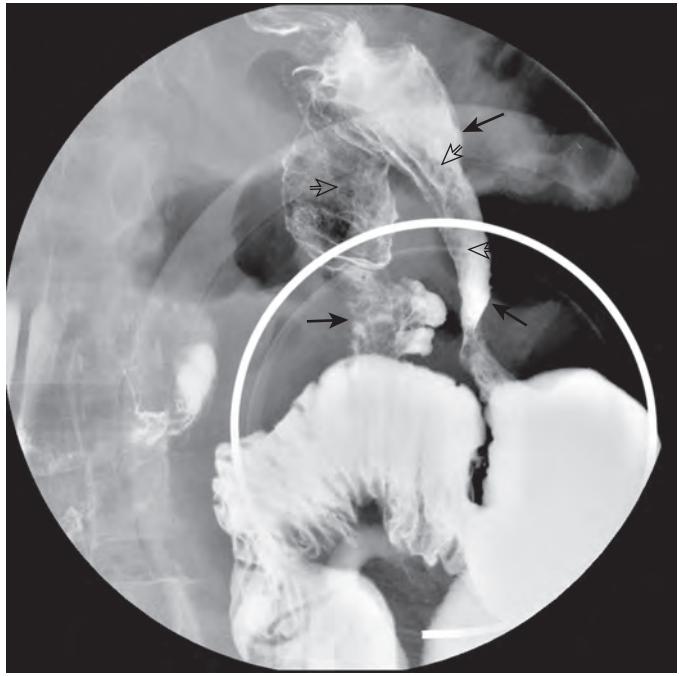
Strongyloidiasis. This spot radiograph from a small bowel follow-through in a patient with a history of partial gastrectomy shows a tubular configuration of the pancreaticobiliary and alimentary limbs (long arrows). Moderate mucosal nodularity is present (open arrows). Saccululation and fold thickening are present in the pancreaticobiliary limb.
